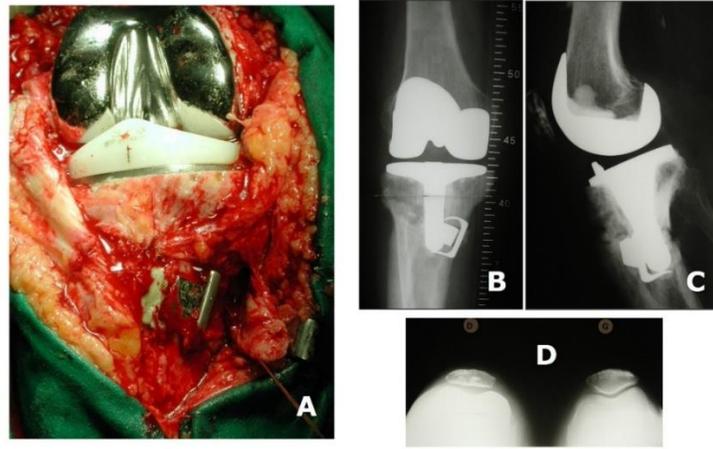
Intraoperative view (A) and postoperative anteroposterior (A), sagittal (B), and patella axial X-rays views (Neyret P)
